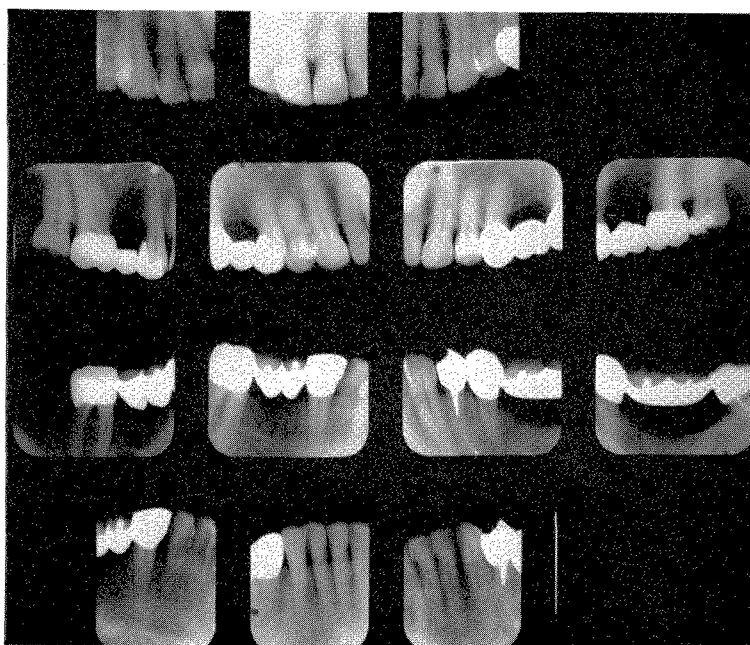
Roentgenograms taken in 1946 upon the completion of new fixed partial dentures.
